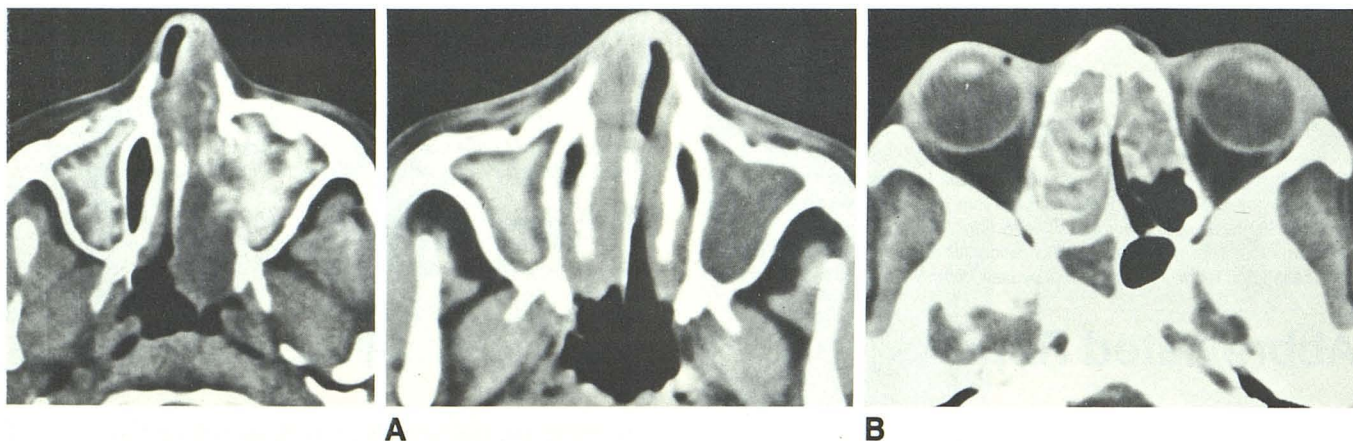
Axial CT scan shows areas of high attenuation in both maxillary sinuses and protrusion of soft-tissue mass from left maxillary sinus into nasal airway.
